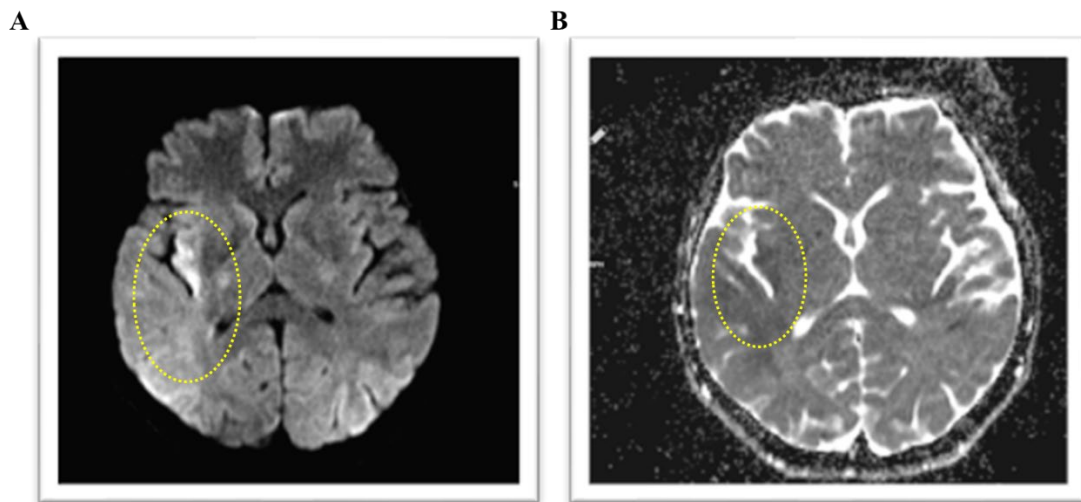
Brain MRI of Case 1 (A) Diffusion and (B) ADC scans showing right MCA stroke and right MCA M1 occlusion (as high lighted by yellow dotted circle).
